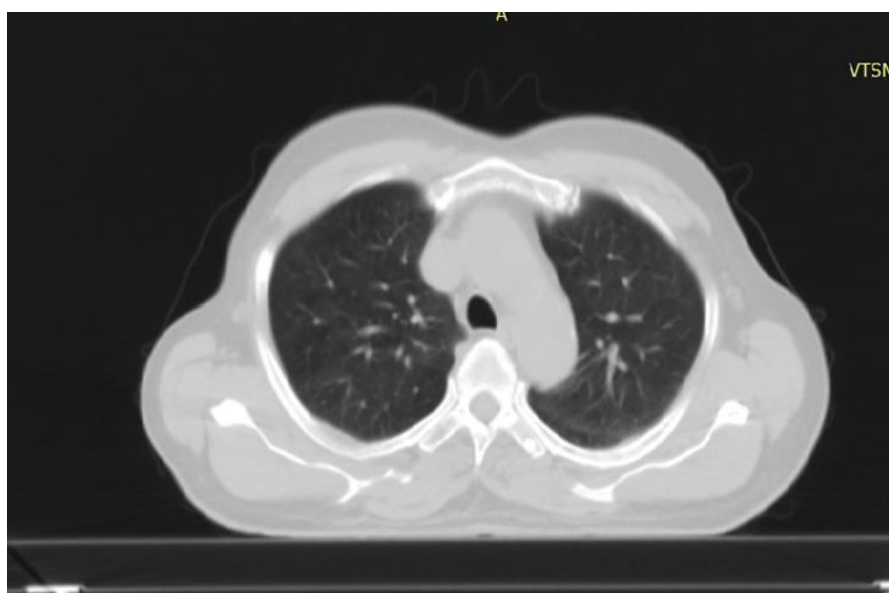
HRCT Thorax (CORADS-1): No abnormality in both lung fields detected
